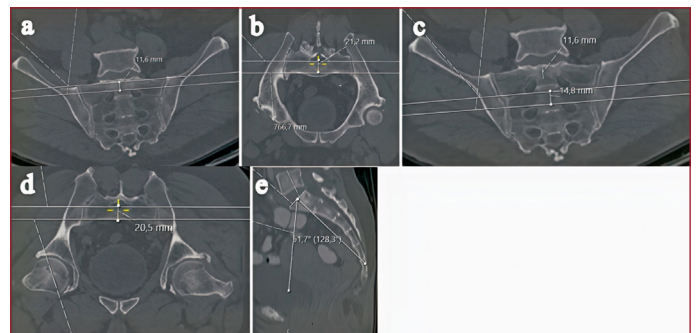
Measurement of the horizontal corridor in the S1 sacral segment on reconstructed CT images. A) S1 CC measurement true coronal (outlet view) B) S1 AP measurement true axial (inlet view) C) S2 CC measurement true coronal (outlet view) D) S2 AP measurement true axial (inlet view) E) Pelvic incidence angle
